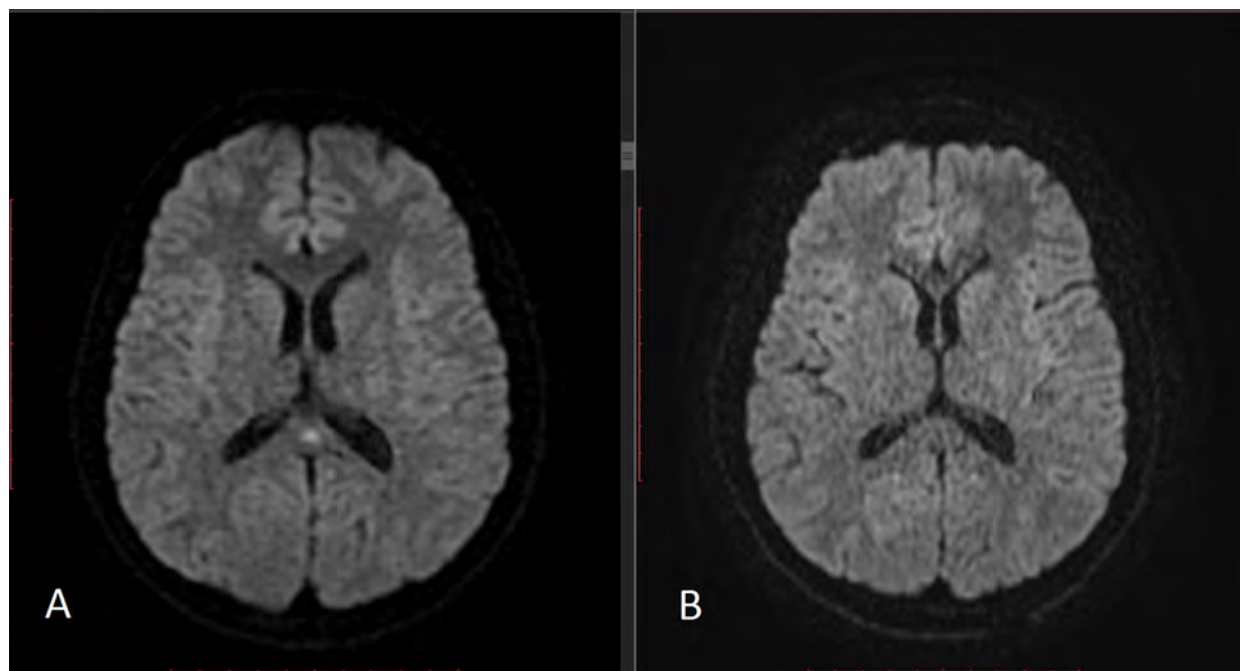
(A) Diffusion restriction in the corpus callosum splenium region (white arrow) in cranial diffusion magnetic resonance imaging of Case 6. (B) Normal findings in control diffusion magnetic resonance imaging of the same case after 14 days.
